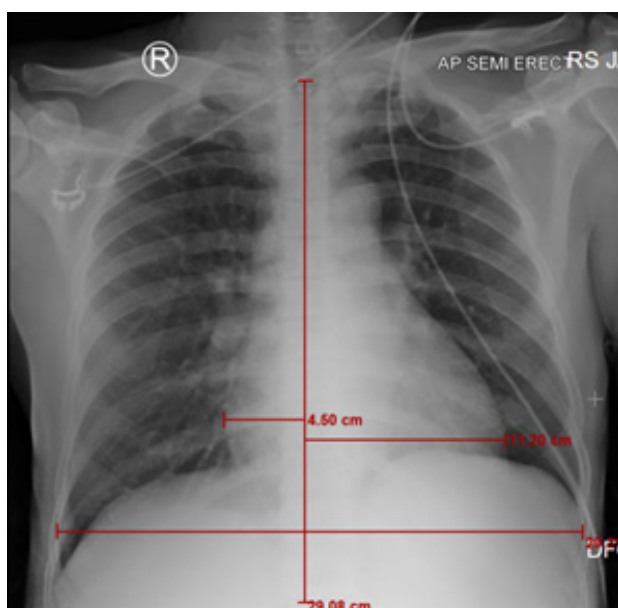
Chest X-ray of patient in NCCHK
